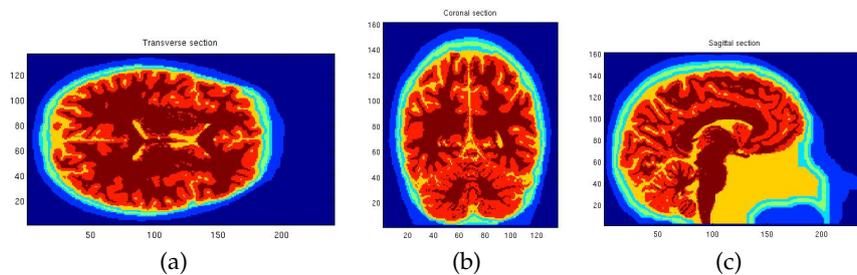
Segmented structural MRI information visualized through ad-hoc MATLAB routine.
